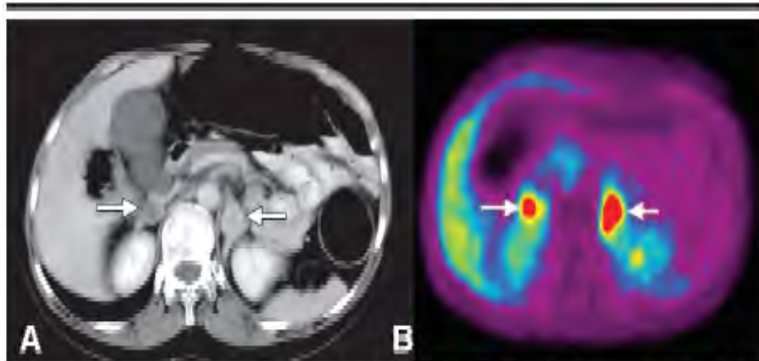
Transverse images obtained in a patient with multiple endocrine neoplasia type 2 and an increase in urinary catecholamine levels. A, CT image shows bilateral adrenal tumors (arrows), a 2-cm-diameter tumor on the right side, and a 4-cm-diameter tumor on the left side. B, HED PET image shows intense uptake in both adrenal lesions (arrows). Surgery revealed bilateral pheochromocytomas.
